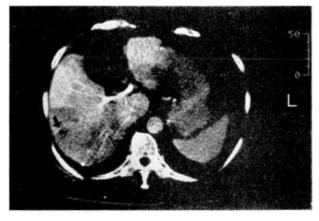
CT during arterial portography image demonstrates the nodule of low-attenuation relative to the surrounding liver (arrow), diagnosed as portal supply negative.
